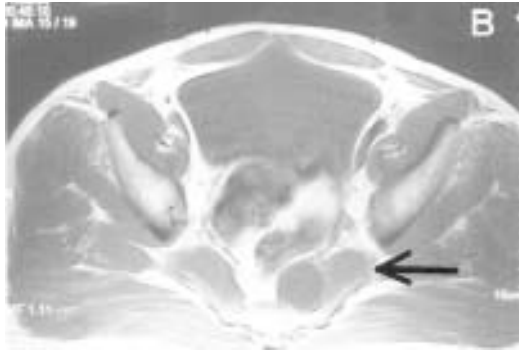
The same cystic lesion on the MRI scan of the lower abdomen and pelvis.
